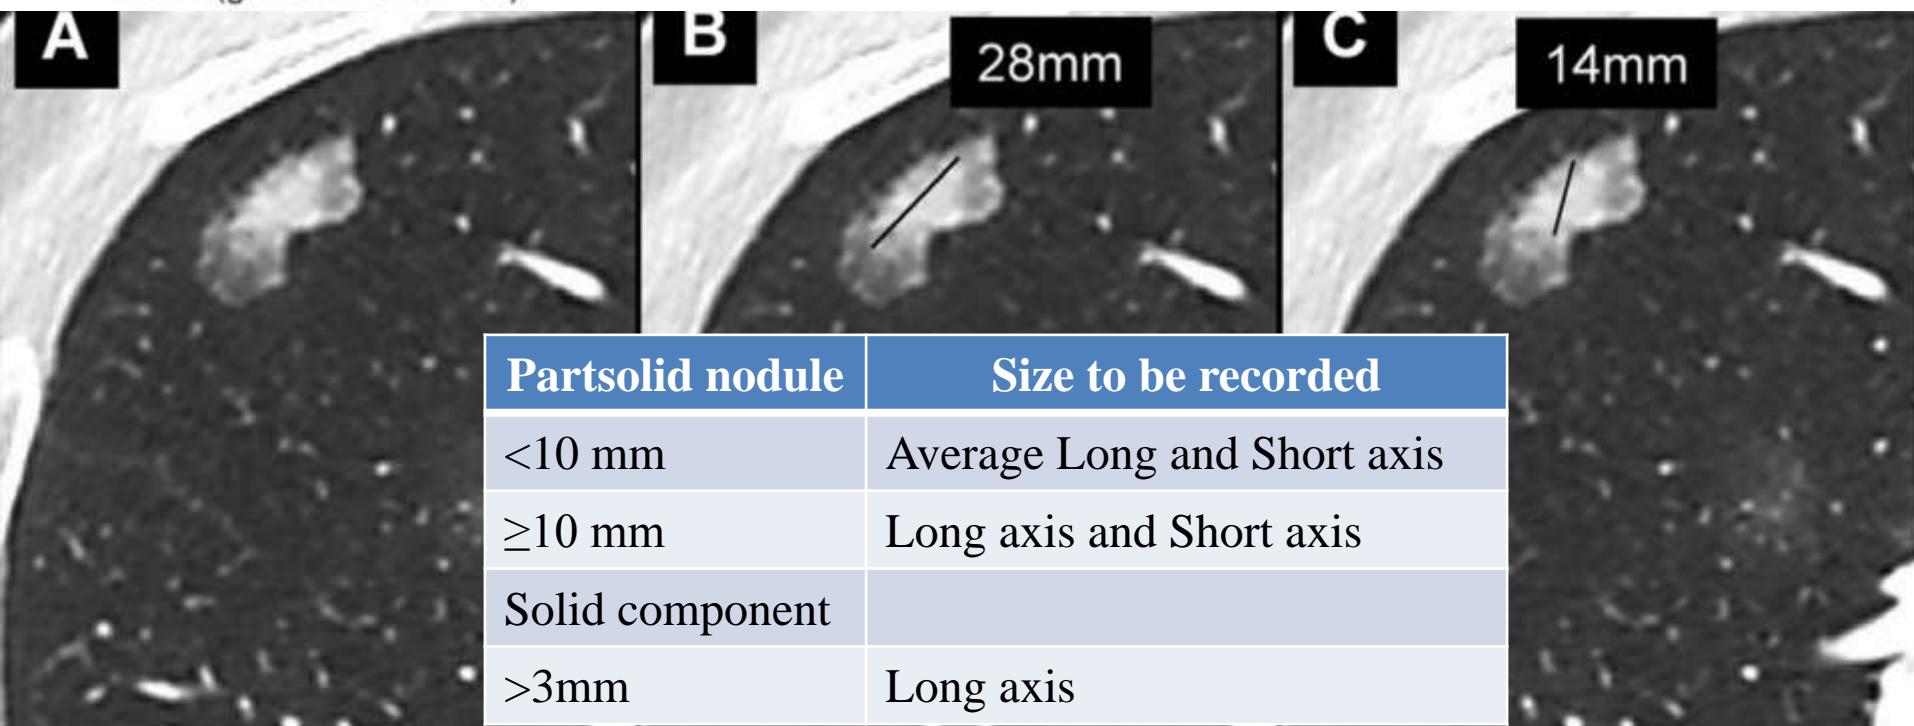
Transverse CT sections of a part-solid nodule in the right upper lobe. *A*, The solid component of the nodule is ill defined, resulting in variability of measurements, as performed by two radiologists. The two long-axis diameters of the solid component were, *B*, 28 mm and, *C*, 14 mm. On the basis of the clinical implications, we recommend use of the larger long-axis diameter. Only solid component measurements are shown in this figure; however, in clinical practice, nonsolid and solid components must be measured.
